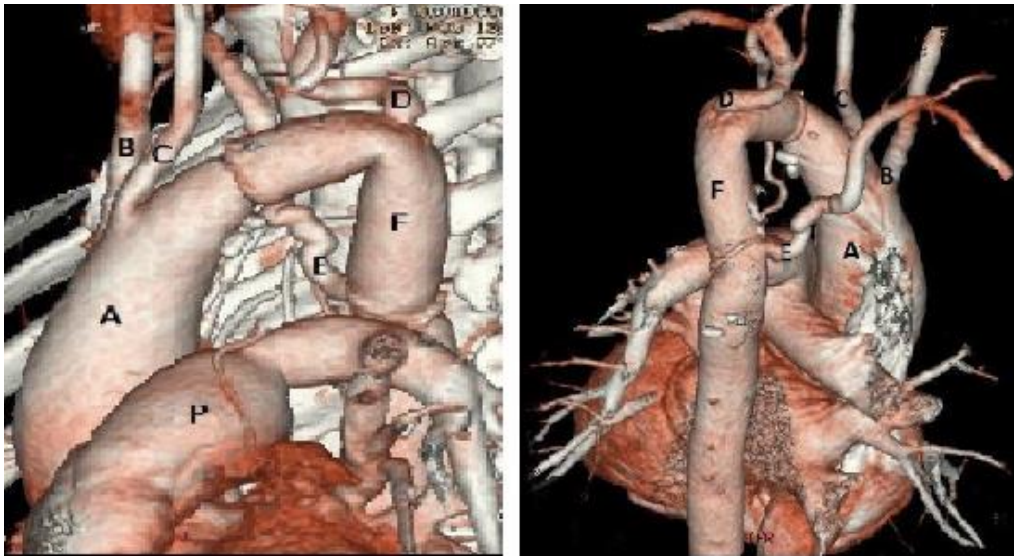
Antero-posterior and posterior-anterior views of 3 D reconstruction of her computed tomography of the new aorta. 90 days after surgery. A- ascending aorta; B-right common carotid artery; C- left common carotid artery; D- left subclavian artery; E- aberrant right subclavian artery; F- the reconstructed vascular graft; P- pulmonary artery.
